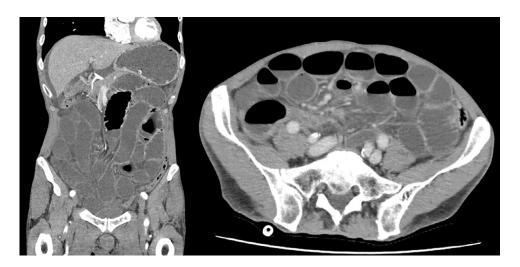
CT scan showed that the entire small bowel was dilated with an air–fluid level, but there were no obvious signs of obstruction.
